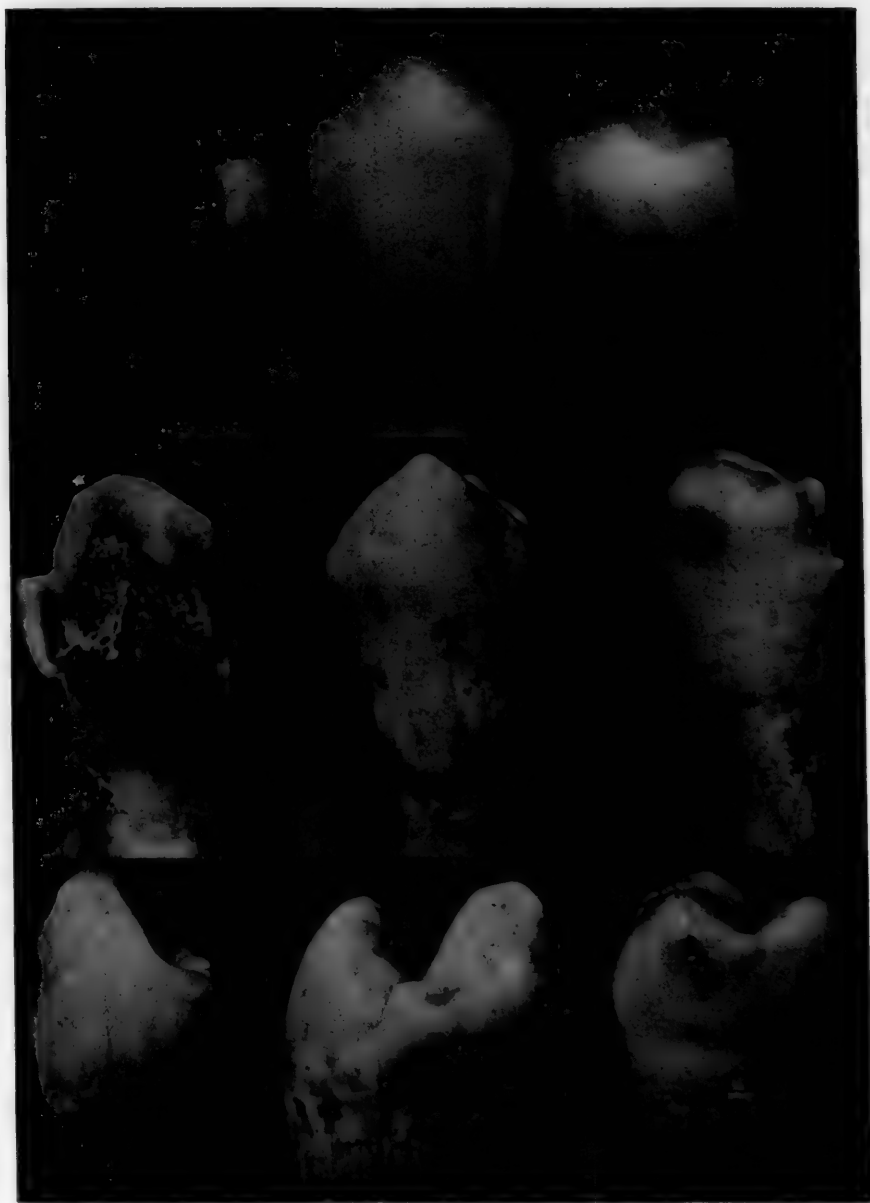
Top row shows x-ray negative of teeth at start of experiment. Middle and bottom rows are photographs of teeth at start of experiment. Column *A* shows views of tooth from patient with rampant caries; Column *B* shows views of tooth from patient immune to caries; Column *C* shows views of tooth from patient with mottled enamel.
